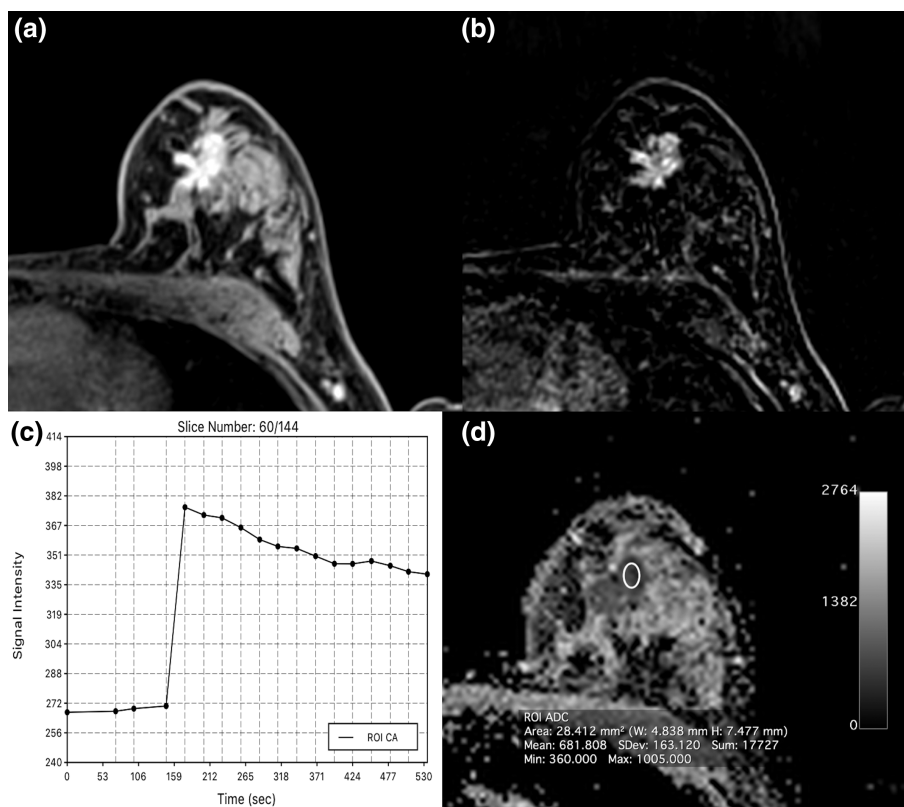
Invasive ductal carcinoma (IDC) grade 3 retroareolar in the left breast in a 47-year-old woman: On DCE-MRI there is a 23-mm (A) irregularly shaped and partly spiculated mass with (B) an initial fast heterogeneous contrast enhancement followed by a washout and (C) decreased ADC values ($0.0681 \times 10^{-3} \text{ mm}^2/\text{s}$) evident.
